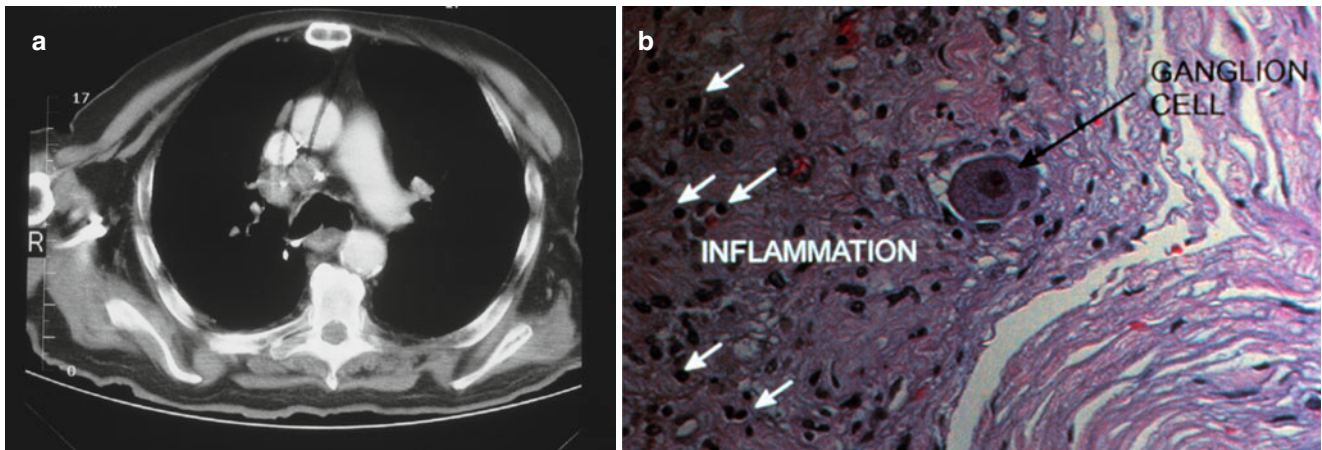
Paraneoplastic ganglionopathy in a patient with small cell lung cancer. (a) Chest X-ray showing enlargement of the mediastinal lymph nodes. (b) Single dorsal root ganglion (*large arrow*) and inflammatory cell infiltrates (*small arrows*)
